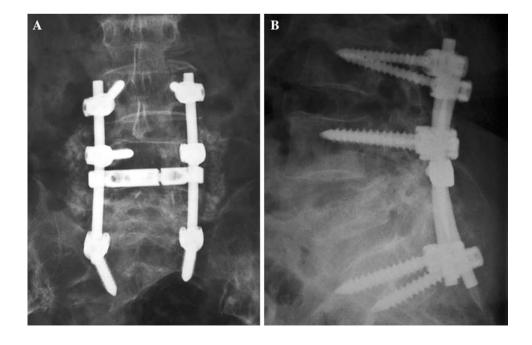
Anteroposterior (a) and lateral (b) postoperative plain radiographs of the lumbar spine showing decompressive laminectomies of L4, followed by posterior spinal fusion with rigid pedicle screw fixation at L3–S1 and autogenous bone graft mixed with hydroxyapatite
